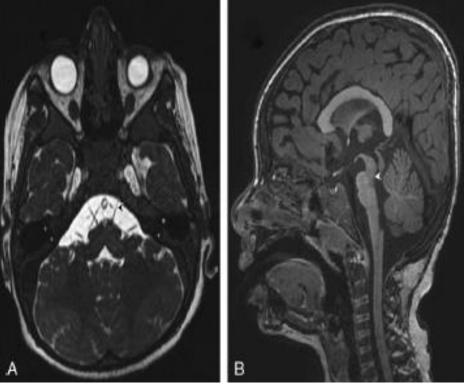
From left to right: A) Axial FIESTA Sequence showing cisternal portion of the abducent nerve (Small Black Arrow) [1] B) Sagittal T1 Sequence showing hypoplastic brainstem with depression of the fourth ventricle (Small White Arrow) [1] (MRI Brain image from Tyradellis et al. [1])
